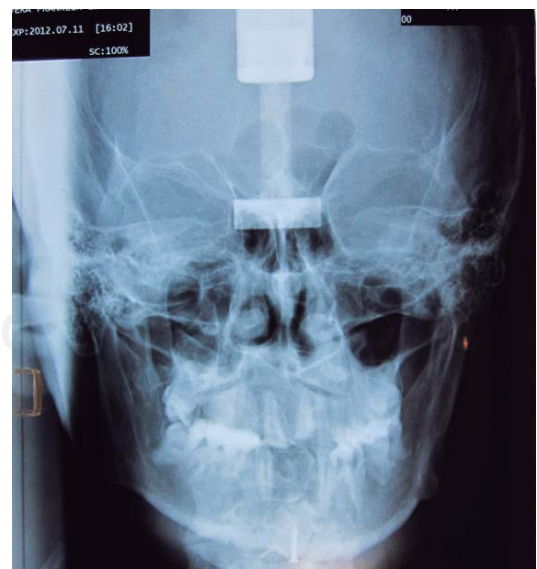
Posteroanterior radiograph. Symmetry is observed with scissor bite on the right side.
